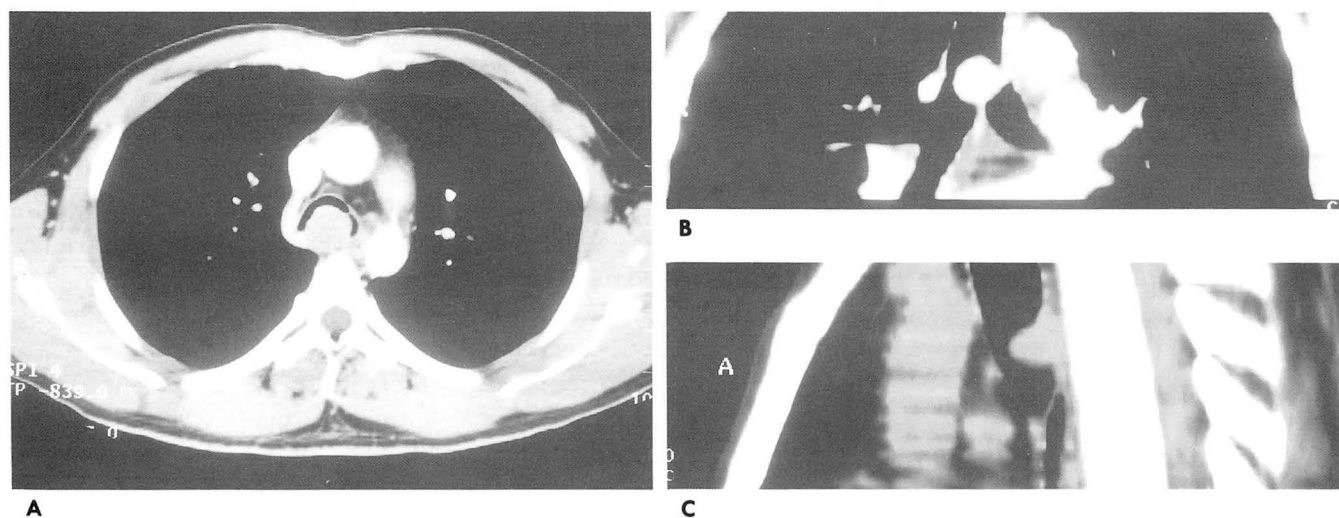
Axial(A) and coronal(B) and sagittal reconstruction(C) CT images demonstrate an approximately 2×2×3cm sized sharply defined intraluminal projecting polypoid mass. The mass has wide attachment to posterior wall of trachea. There is no evidence of extraluminal involvement.
